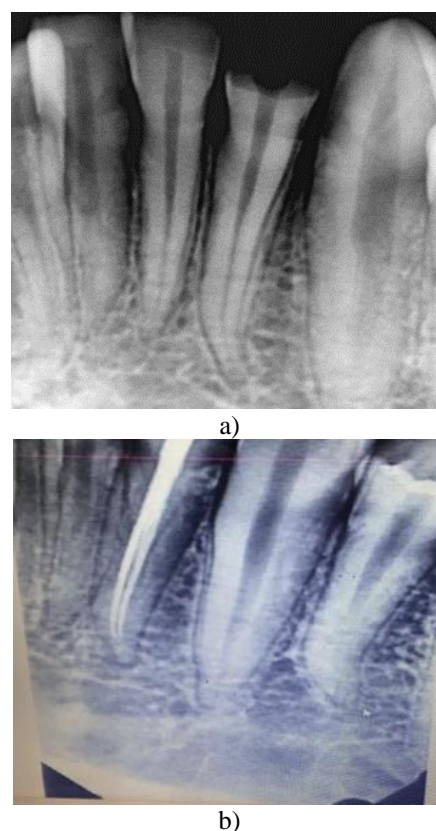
a) Preoperative radiograph with suspected two canals due to abrupt thinning of canal in the middle third. b) Post operation radiograph shows well-obtured radiograph with Vertucci type V configuration
